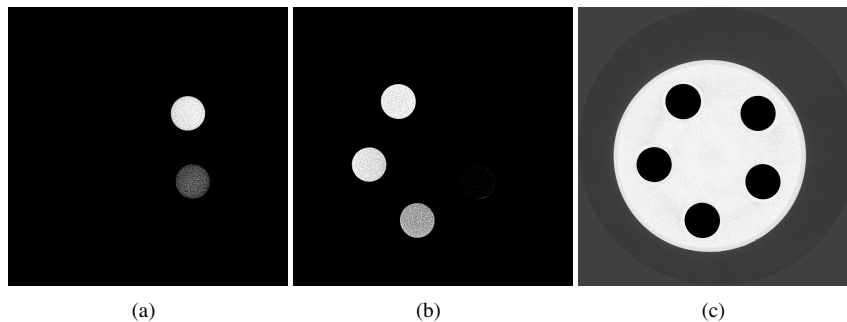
Decomposition in three basis materials of the CT slices from figure 4.15 showing the calculated volume fractions of the PTA solution (a), the KBr solution (b) and water (c). A threshold of 0.5 was applied for each image.
